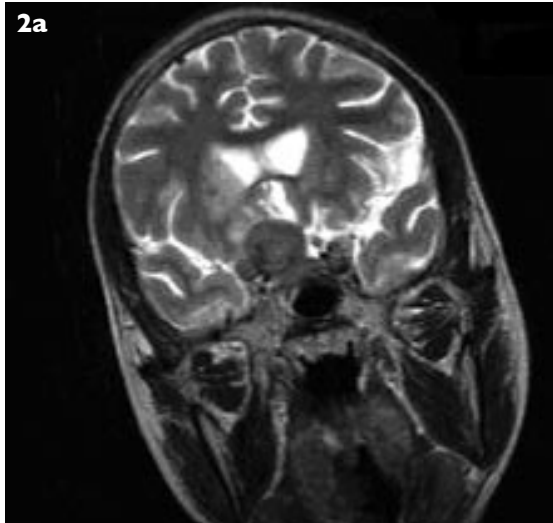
(a) Coronal T2-W MR image shows a hypointense, suprasellar mass and an infarct. (b) Enhanced axial T1-W image shows a pituitary mass with peripheral enhancement.
